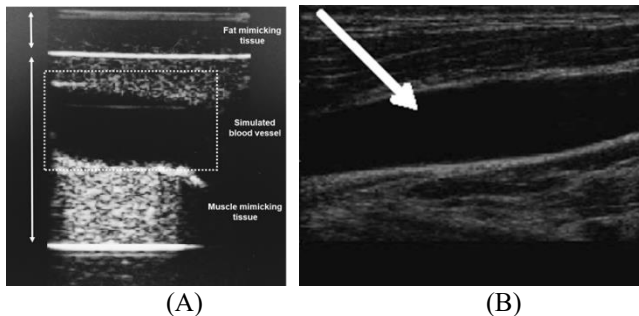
SAGITTAL VIEW OF INTERNAL JUGULAR VEIN, (A) ULTRASOUND IMAGE OF CVC OPERATIONAL PART, (B) ULTRASOUND IMAGE ACQUIRED FROM THE REAL CASE [10]
